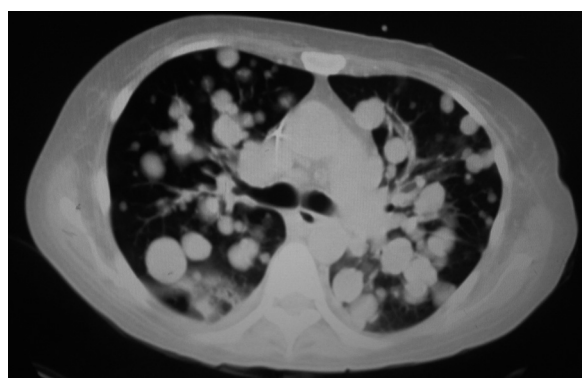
61 year-old woman die from lung metastasis from malignant fibrous histiocytoma of the distal femora 7 weeks after finding the leukemoid reaction. Chest CT scan shows innumerable pulmonary nodules with "cannonball" morphology.
